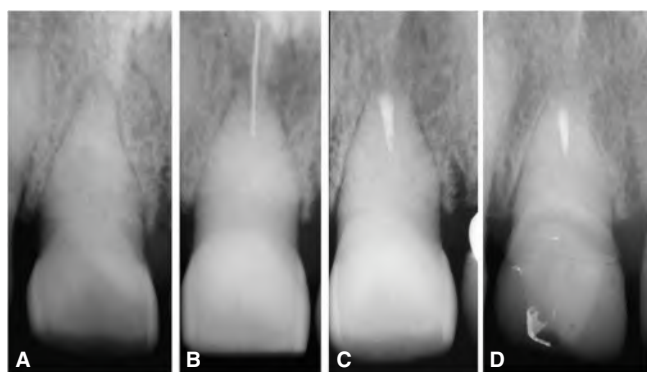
Surgical endodontic treatment in a maxillary central incisor of a 42-year-old female. The patient reported spontaneous pain in this tooth. A. Preoperative radiograph showing evidence of a calcified root canal system. B. Intraoperative radiograph during retro-instrumentation of the accessible portion of the root canal. C. Immediate postoperative radiograph showing the retro-obturation of the root canal with thermoplasticized gutta-percha and sealer. D. 18-year follow-up. Periradicular normalcy can be observed.
